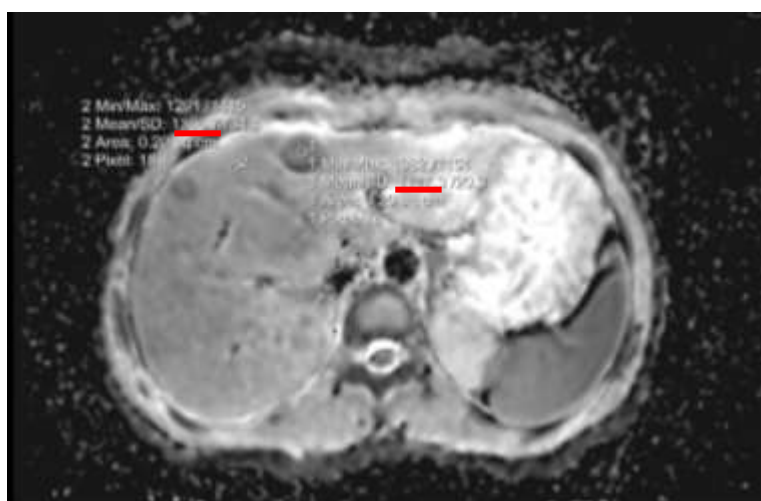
38 female patient with breast cancer showing HFLs on metastatic workup. Dynamic MRI was done this figure showing ADC map of liver showing HFLs and ROIs were applied on both HFL (ROI 1 reading 1117) and on liver parenchyma (ROI 2 reading 1366). ADC ratio = 0.81
